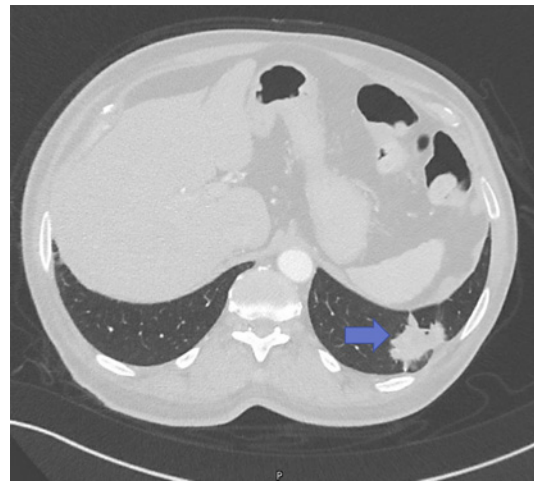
CT chest (lung window) showed left lower lobe mass (blue arrow).
